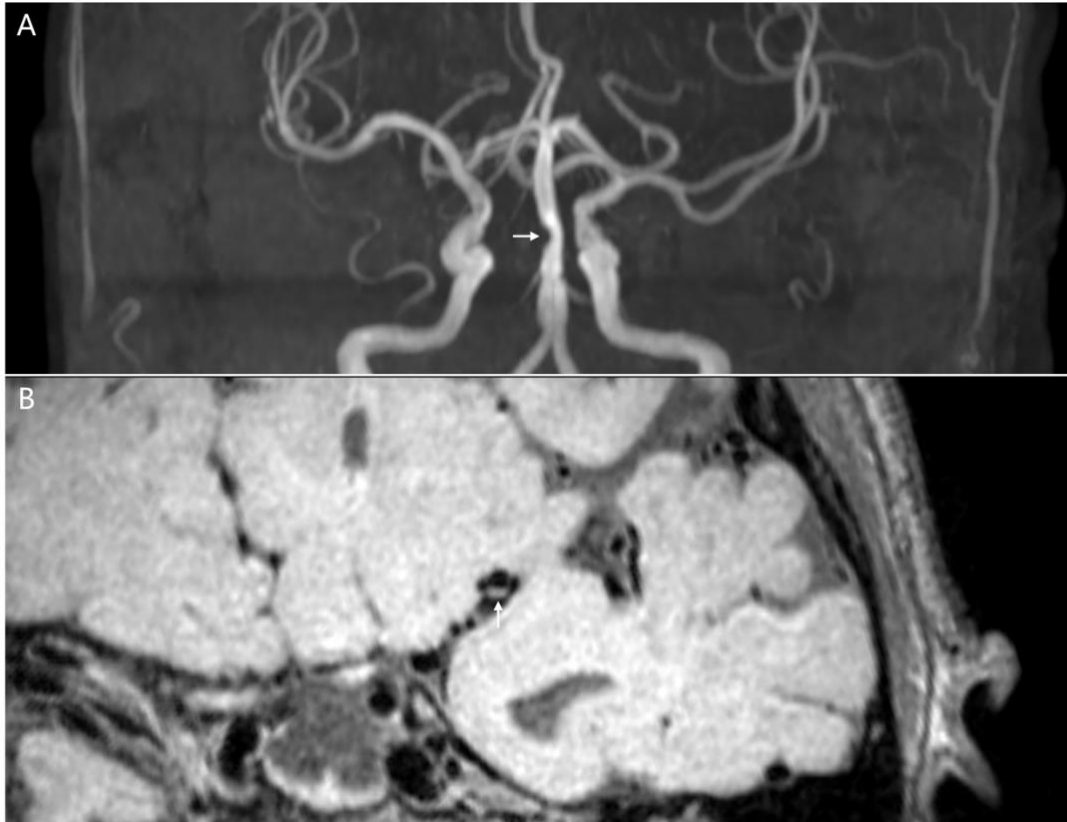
A 72-year-old male patient with acute infarction in posterior circulation. A, a symptomatic atherosclerotic stenosis of the BA on MRA imaging (white arrow). B, an eccentric, focal plaque in the right MCA-M1 as an asymptomatic atherosclerotic lesion on T1w imaging (white arrow). BA, basilar artery; MCA, middle cerebral artery; MRA, magnetic resonance angiography; T1w, T1-weighted.
